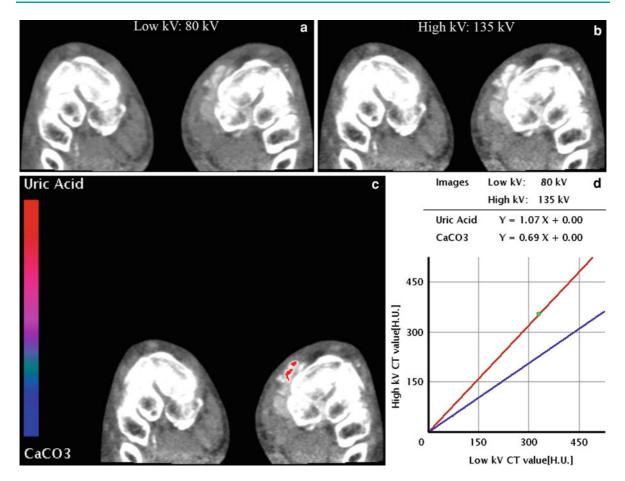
Dual-energy CT of a 66-year-old man with tophaceous gout of the feet. Examination performed with a 320-detector row CT with acquisition of two successive volumes of 16 cm focusing on feet/ankles and hands/wrists in 80 kV/217 mAs (a) and 135 kV/37 mAs (b) (collimation of 320 \times
